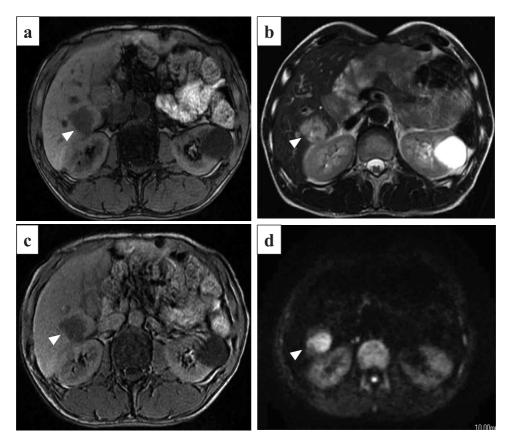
Enhanced MRI, showed the tumor as a low intensity lesion on T1- (a) and SPIO T1-weighted (c: arrow) images, and as a high intensity lesion on T2- (b) and diffusion-weighted (d: arrowhead) images.
